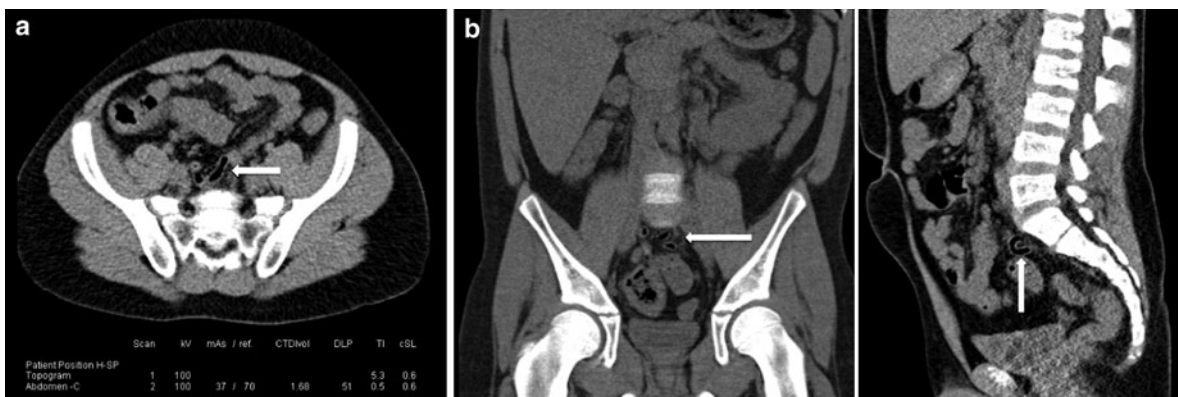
Unenhanced MDCT obtained at 100 kV in a 12-year-old boy after two consecutive inconclusive (*or negative*) ultrasound examinations. a in axial orientation and b in coronal and sagittal orientations show a normal appendix (*arrows*).
